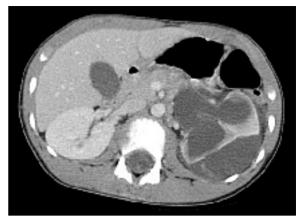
Delayed CT with intravenous contrast demonstrating a large perinephric urinoma in an 8-year-old boy who presented to hospital with gross hematuria following a fall. Note the thinned parenchyma and severe hydronephrosis consistent with chronic obstruction
